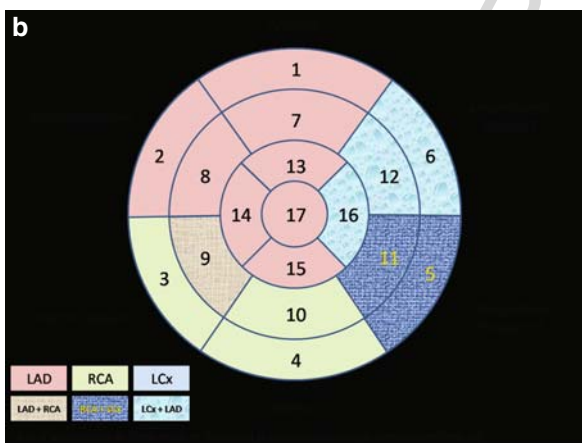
Bull's eye plot of myocardial segments. A represents left ventricular assignments to coronary territory based on data from the 2002 American Heart Association consensus statement.⁶ B represents left ventricular assignments to coronary territory based on data from the 2005 consensus statement by the American Society for Echocardiography and the European Association for Echocardiography.⁹
